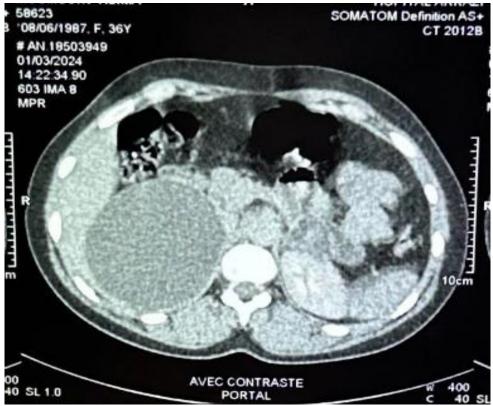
CT image showing a right adrenal cyst
